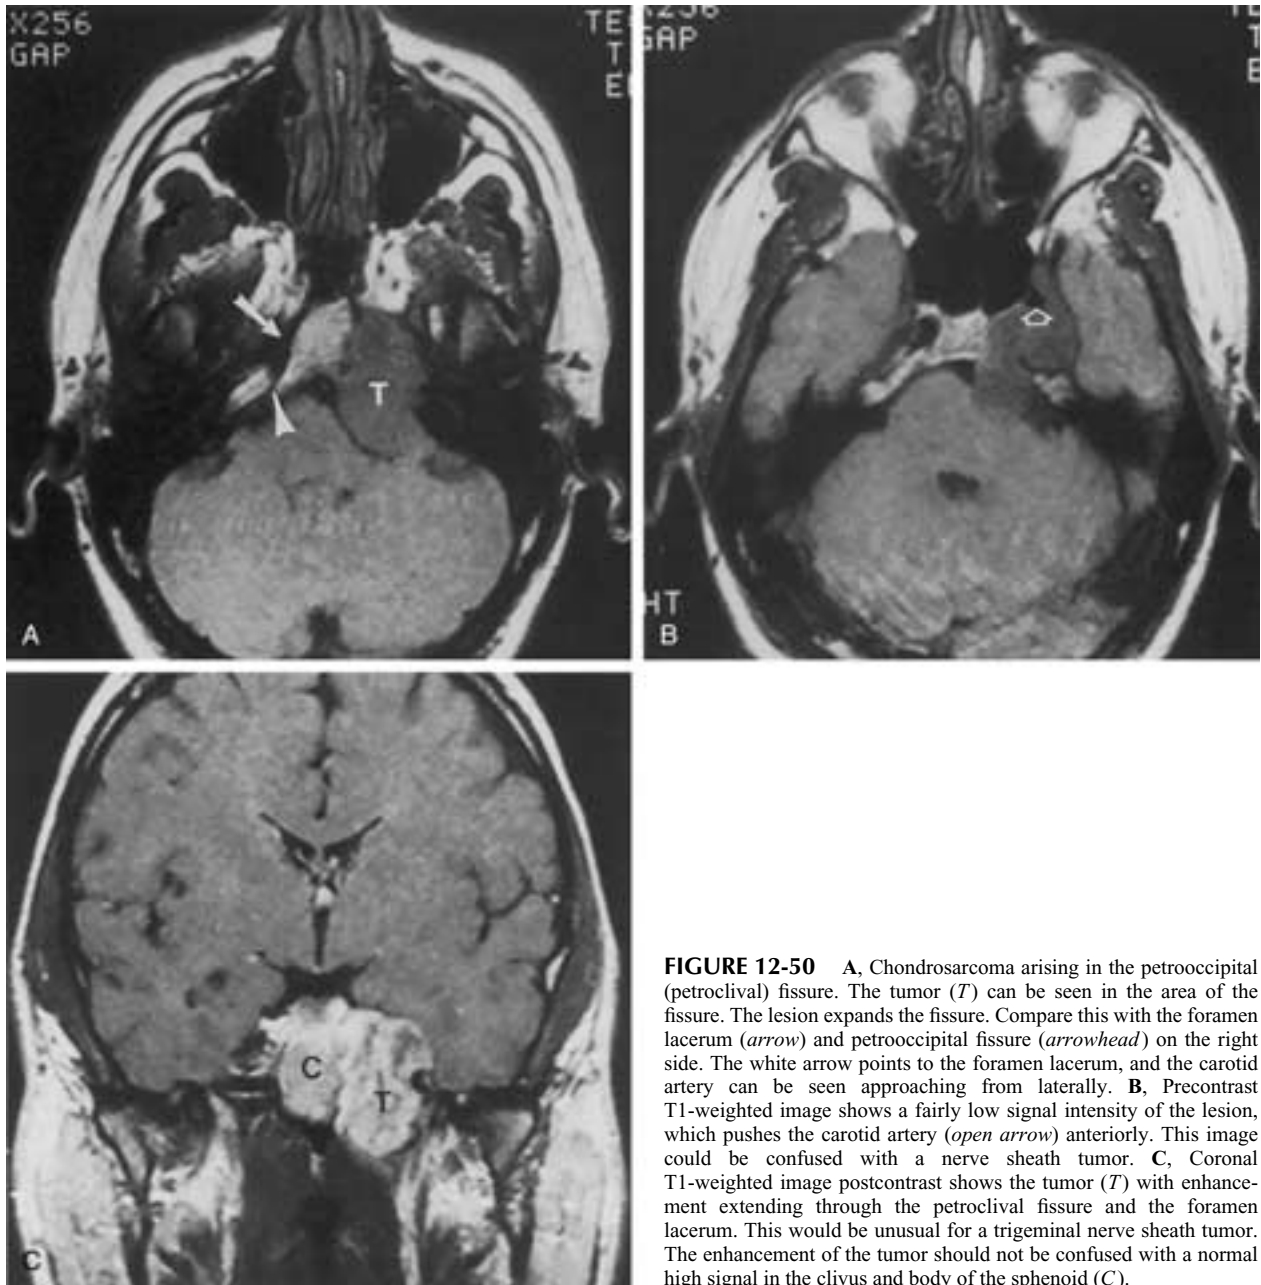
A, Chondrosarcoma arising in the petroocipital (petroclival) fissure. The tumor (*T*) can be seen in the area of the fissure. The lesion expands the fissure. Compare this with the foramen lacerum (*arrow*) and petroocipital fissure (*arrowhead*) on the right side. The white arrow points to the foramen lacerum, and the carotid artery can be seen approaching from laterally. B, Precontrast T1-weighted image shows a fairly low signal intensity of the lesion, which pushes the carotid artery (*open arrow*) anteriorly. This image could be confused with a nerve sheath tumor. C, Coronal T1-weighted image postcontrast shows the tumor (*T*) with enhancement extending through the petroclival fissure and the foramen lacerum. This would be unusual for a trigeminal nerve sheath tumor. The enhancement of the tumor should not be confused with a normal high signal in the clivus and body of the sphenoid (*C*).
